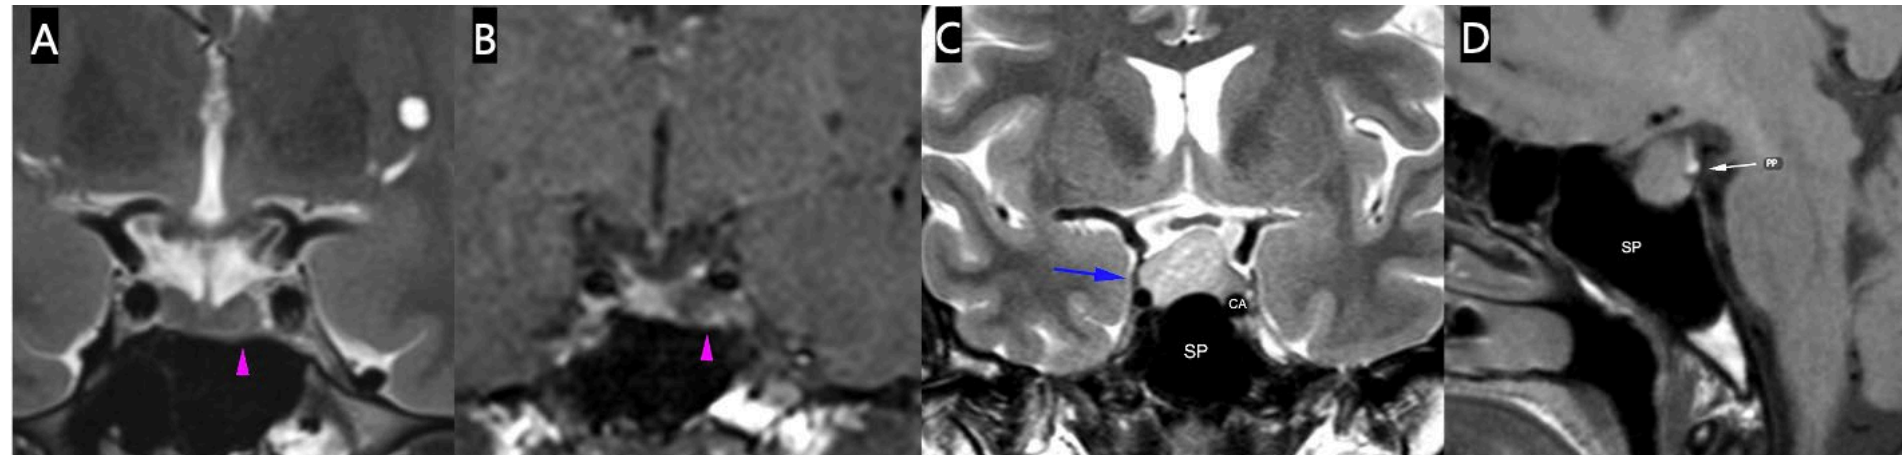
Coronal and sagittal MR images of two different patients. Images A and B show a pituitary micro-adenoma (purple arrowheads) seen as a slightly hyperintense image on the T2W sequence (A) and as a focal hypo-enhancing region on the fat suppressed T1W image (B). Macro-adenoma appearing as a hyperintense mass on the coronal T2W (C) with extension to the right cavernous sinus (blue arrow) and surrounding the internal carotid artery. The lesion is isointense on the sagittal T1W image (D). On D, the tumor has a mass effect on the neurohypophysis that appears as a bright spot on the non-contrast T1W image (white arrow). SP = sphenoid sinus. CA = Internal carotid artery.
